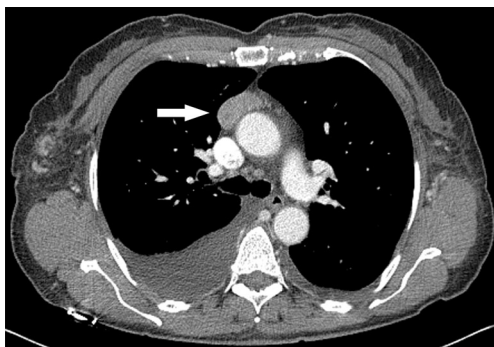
CT chest showing 3.1×1.5 cm indeterminate low-attenuation lesion (*arrow*) in the anterior mediastinum
